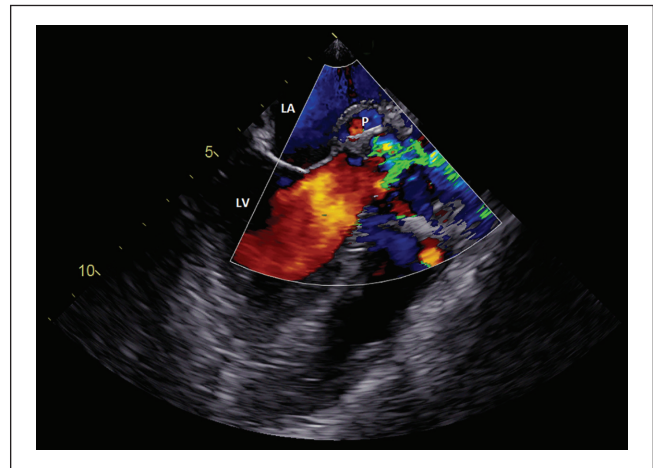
Transesophageal echocardiography showing bicuspid aortic valve (A) and the pseudoaneurysm of the mitral–aortic intervalvular fibrosa (P) in systole (left) and diastole (right).
